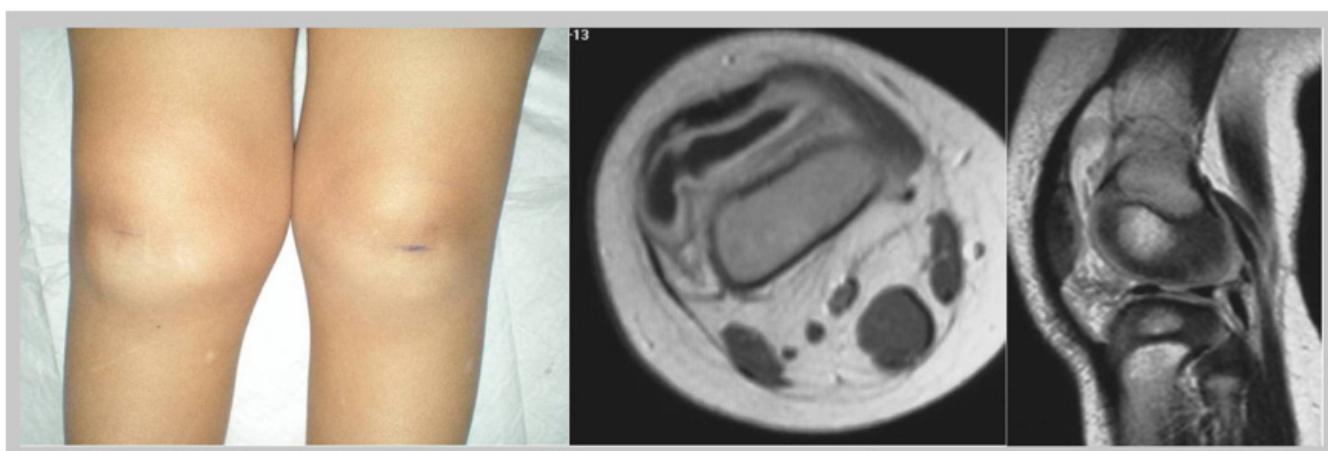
A 21-month-old girl presented with a painful right knee swelling and refusal to walk (left view). MRI showed joint effusion and enhancing synovial hypertrophy in the suprapatellar recess on the T1-weighted axial view after gadolinium contrast administration (middle view). No epiphyseal erosions or subchondral cysts were detected on the T2-weighted sagittal view (right view).
